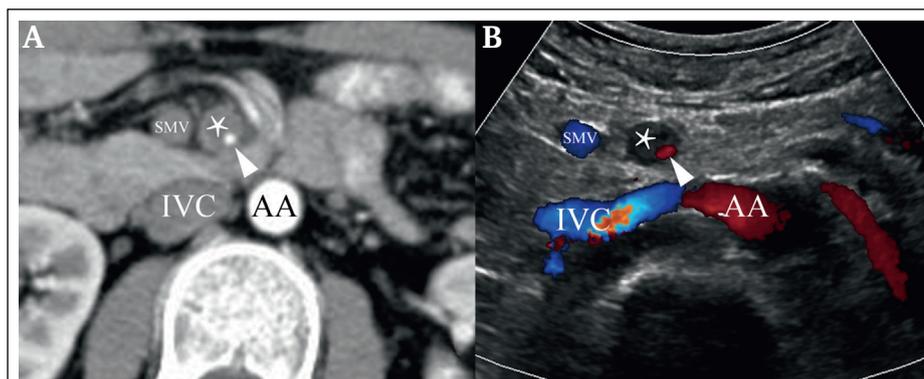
Imaging findings in a patient with a thrombosed false lumen. (A) Cross sectional computed tomography angiography image of the superior mesenteric artery shows that the true lumen (arrowhead) is compressed by the thrombosed false lumen (star). (B) Luminal stenosis (arrowhead) and a thrombosed false lumen (star) can be seen on a colour duplex ultrasound image obtained three days later. AA = abdominal aorta; IVC = inferior vena cava; SMV = superior mesenteric vein.
